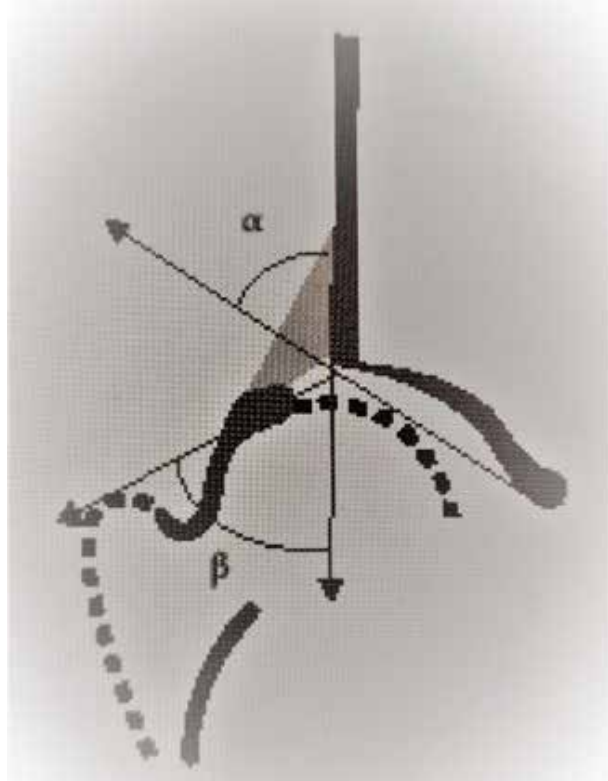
Angles α and β in Graf ultrasonography method
